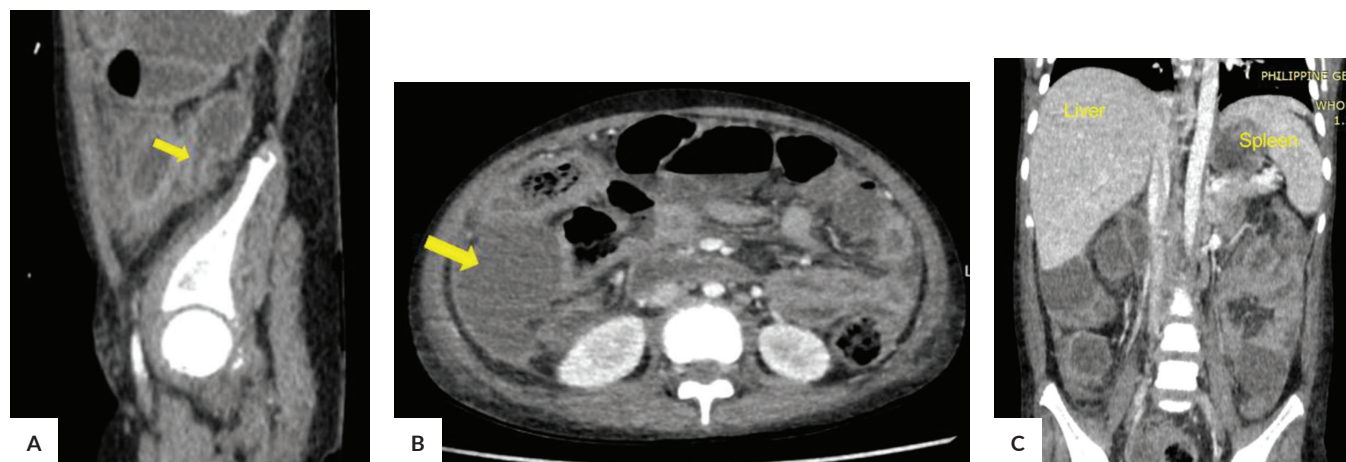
Abdominal CT scan findings taken on the third month of anti-TB treatment showing (A) Dilated appendix (yellow arrow), (B) Peripherally enhancing intraperitoneal fluid collection, suggestive of abscess formation (yellow arrow), (C) Signs of improvement such as regressing peritonitis, regressing liver, spleen, and lymph node sizes.
